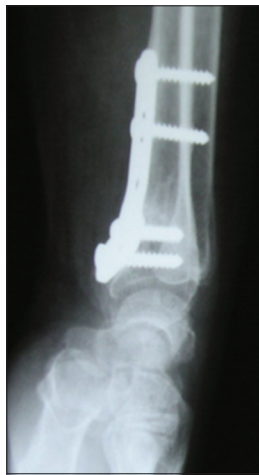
Follow-up X-rays showing stabilization of kienbock's disease (brown arrow)
